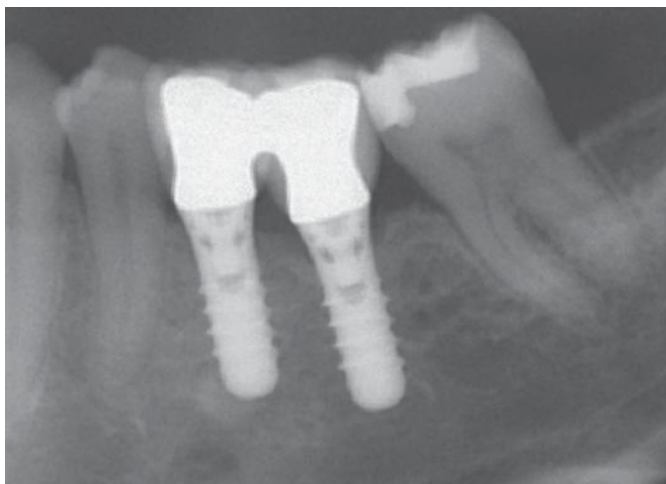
(a) Vestibular aspect of a metal–ceramic restoration supported by two screw-type implants. Due to an excess of mesiodistal space, the implants have been separated by approximately 4 mm. Instead of a traditional pontic, a root imitation has been performed close to the distal implant, providing an adequate guide for an interdental brush in view of an efficient plaque control at the marginal area of the implant restoration. (b) With respect to cleanability, the prosthesis design is clearly visible on the postoperative radiograph. (c) On an oblique view, the vestibular axial profile of the implant restoration becomes visible. Soft tissue (cheek and tongue) support and harmony with adjacent teeth are of paramount importance.
